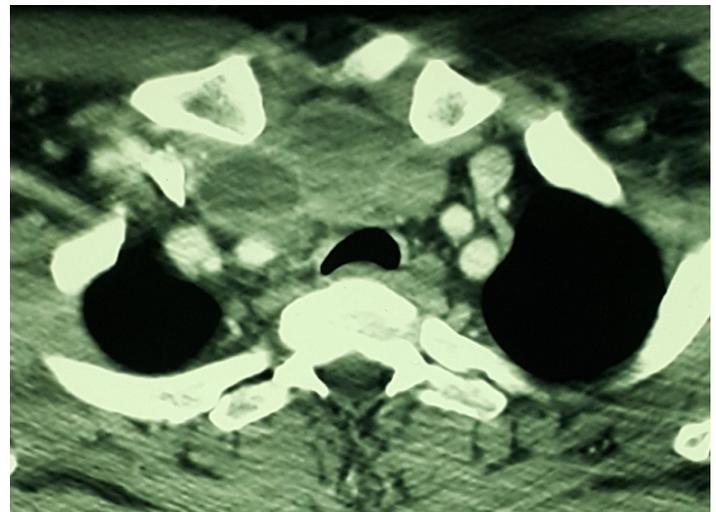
Hypodense Mass Lesion Within the Thyroid Gland Arising from The Right Thyroid Lobe in The Neck CT
